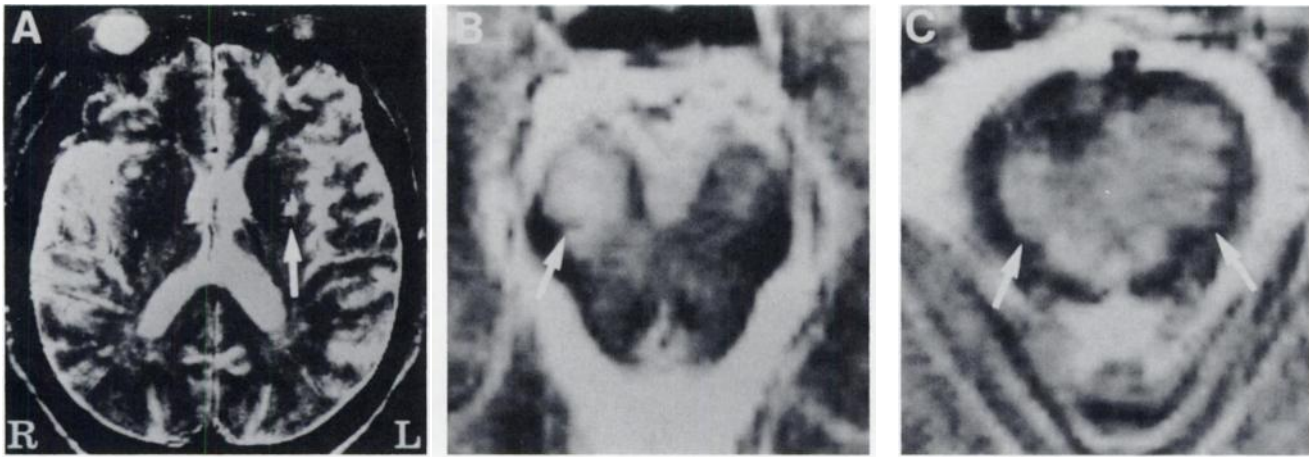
Axial T2-weighted MRI (TR 3000 ms/TE 90 ms) performed on Day 4 after the onset of symptoms. (A) At the level of the basal ganglia and thalamus, the arrow shows a hypersignal in the left basal ganglia. (B) At the level of the cerebral peduncle, the arrow shows a hypersignal in the right cerebral peduncle. (C) At the level of the mid-pons, the arrows show a bilobar hypersignal in the ventral and tegmental portions of the pons.
